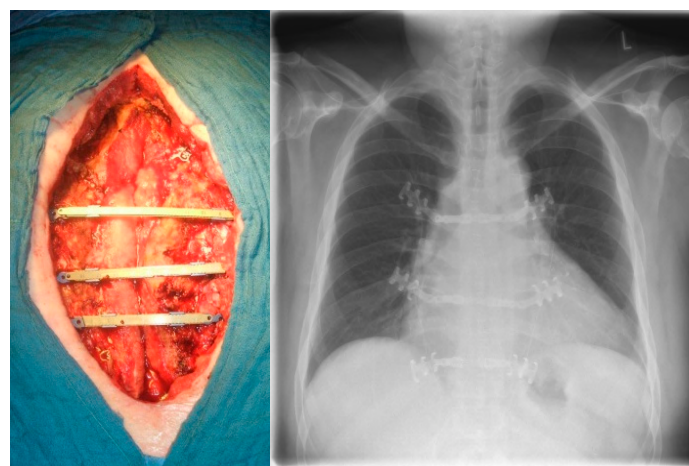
Osteosynthesis for grade III with stabilization at distance. (Left) Intraoperative situs showing three titanium implant bridges. (Right) Postoperative chest X-ray.
